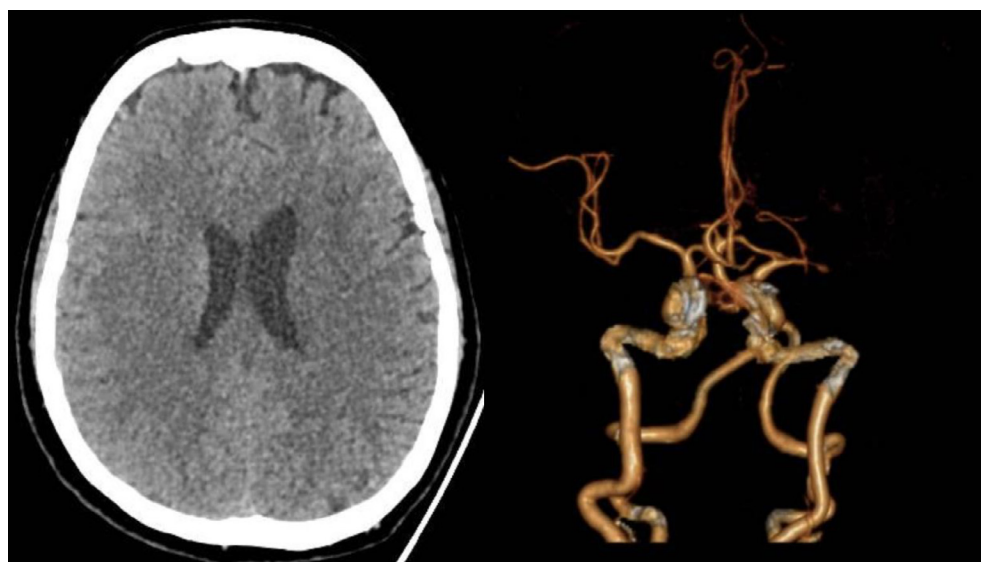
(A) Plain cranial CT scan shows subtle hypodensity on the Left Corona radiata and Centrum Semiovale denoting acute infarction. (B) CT angiography shows atherosclerotic intracranial arteries with significant stenosis at the M1 segment of the MCA.
